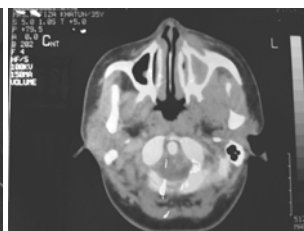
2 CT scan shows left maxillary sinus involvement
